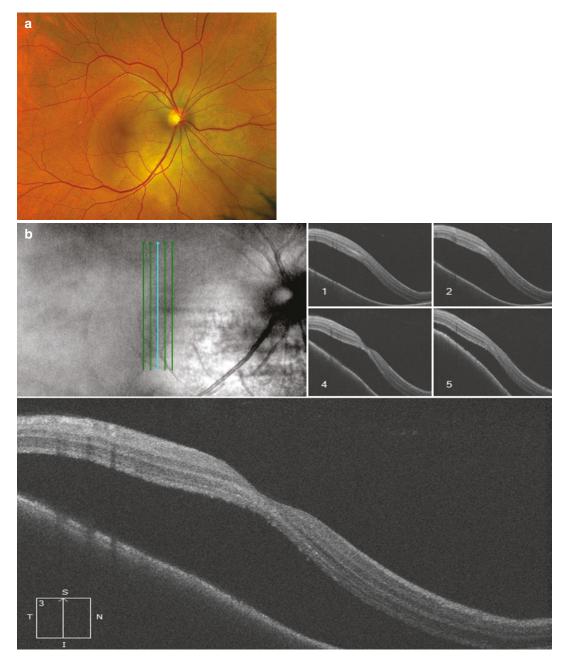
A 61 year old female with stage 4 adenocarcinoma of the lung, positive for EML4-ALK gene translocation diagnosed 2 years ago and complicated by malignant pleural effusion status post chemotherapy and targeted therapy, currently on Crizotinib, presented with blurry vision in the right eye of 3 weeks. Most recent staging CT showed slight increase in pleural metastasis. Ophthalmic exam showed decreased vision in the right (20/400) compared to left (20/20) with normal anterior segment findings. Right eye fundus examination revealed
